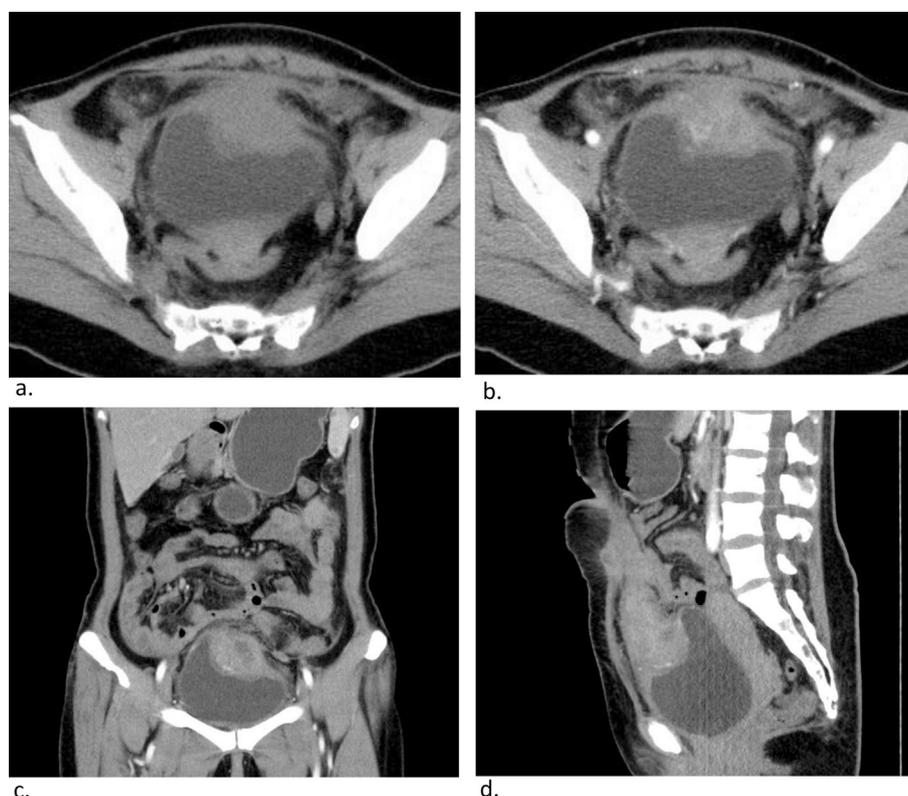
(a–d) Preoperative contrast material–enhanced CT images. b. arterial phase.
